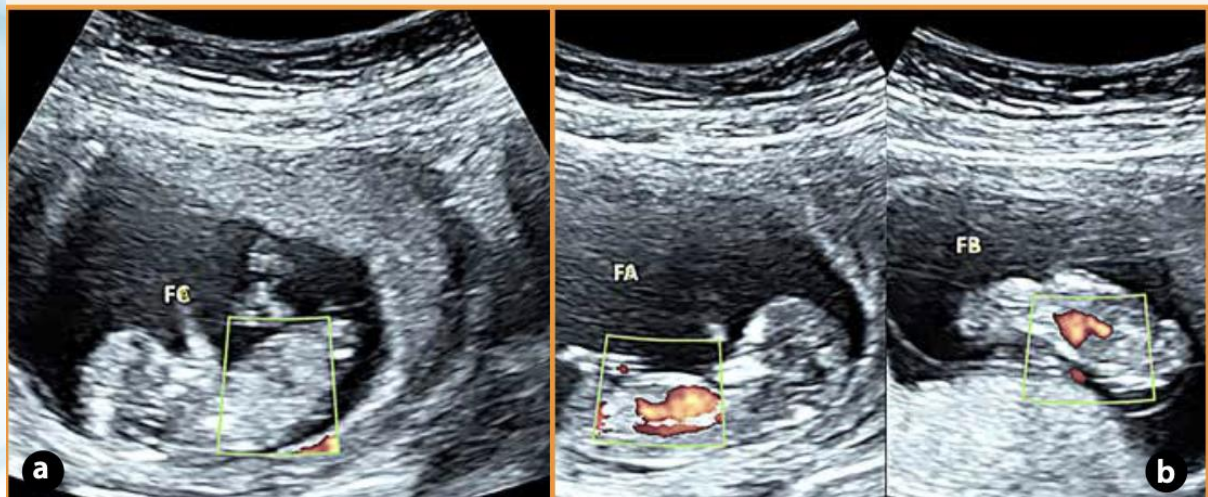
Fetal reduction showing asystole in the selected fetus (Fetus C) on power Doppler *a*. Other two fetuses (Fetus A) and (Fetus B) show viability on power doppler (*b*).
